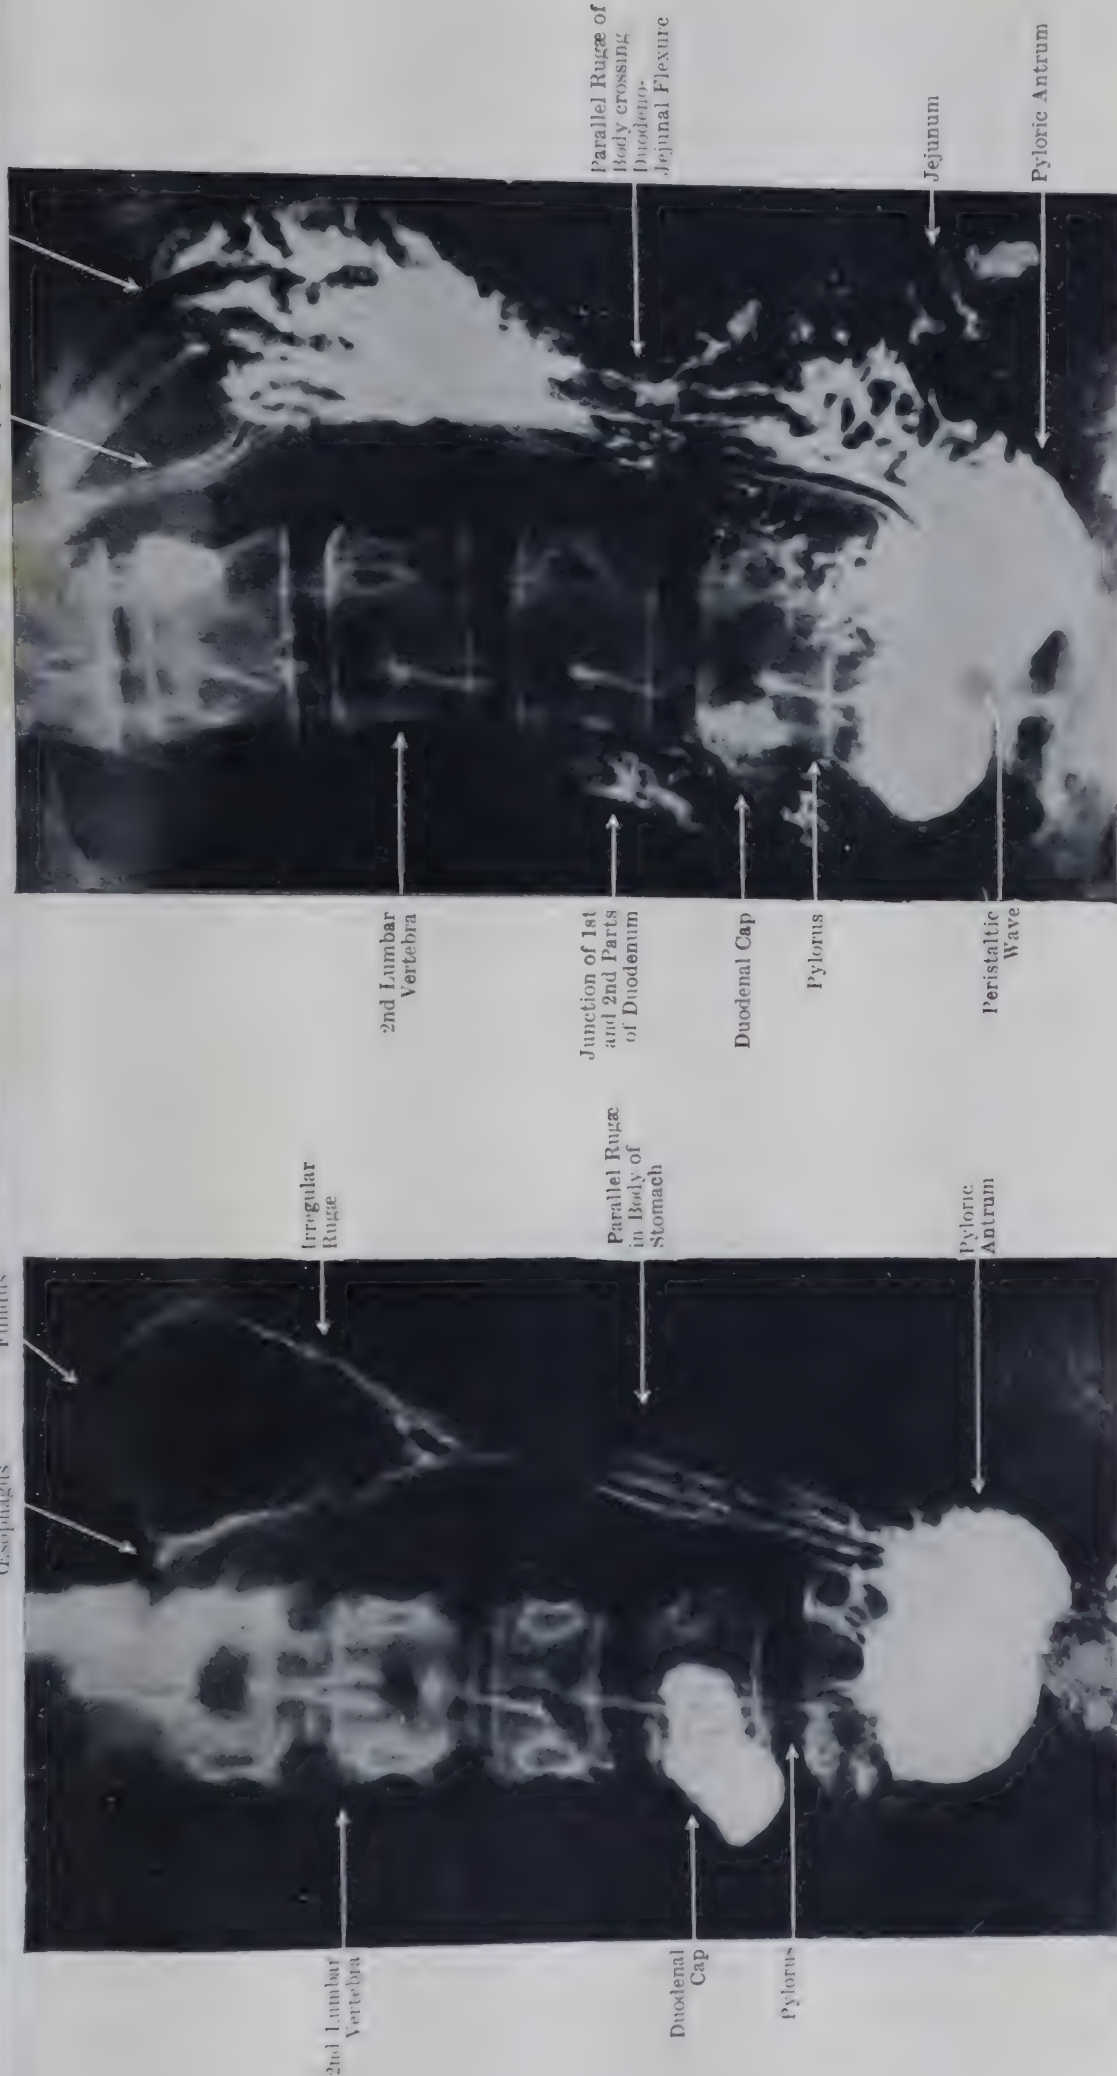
RADIOGRAPH OF NORMAL J-SHAPED STOMACH (WOMAN, AGED 39), SHOWING THE GASTRIC RUGAE MADE EVIDENT BY A SMALL AMOUNT OF BARIUM.
